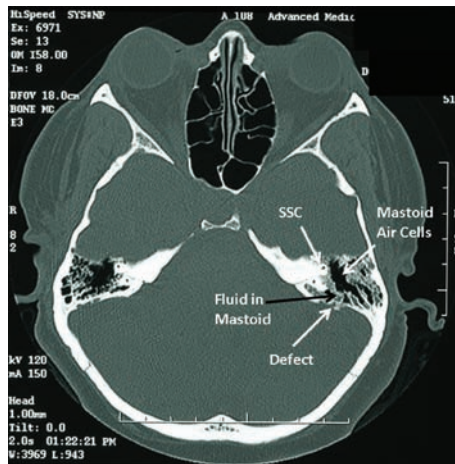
Axial CT image of the patient at the superior semicircular canal (SSC) level. The defect is of the bone separating the posterior fossa dura from the mastoid, which has caused cerebrospinal fluid to enter the mastoid.
